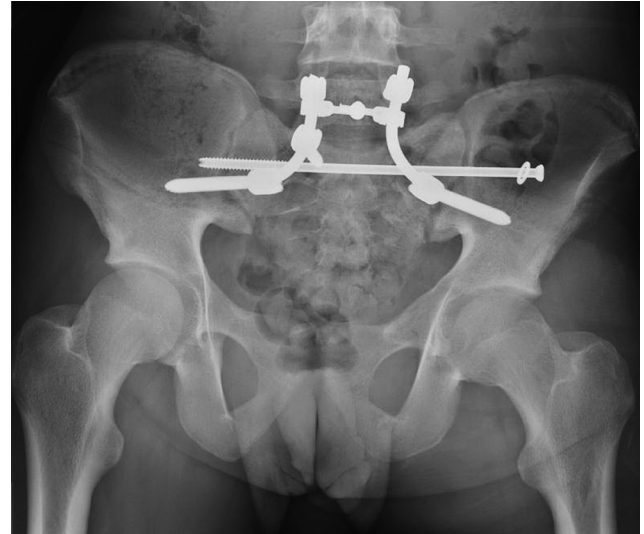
Case 2: Postoperative X-ray showing L5-ilium posterior spinal fusion and instrumentation with trans-sacral screw.
